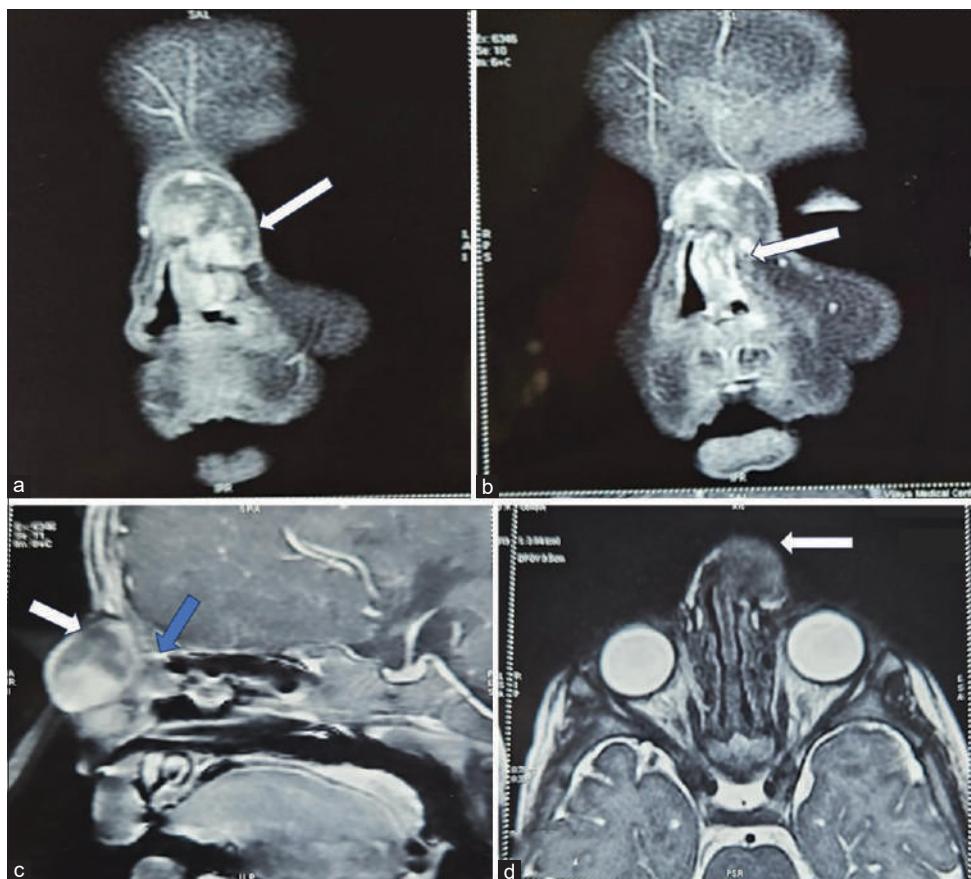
Contrast-enhanced magnetic resonance imaging (MRI) T1 images of paranasal sinuses in the coronal sections (in anterior most plane) showing (a) widening of the nasal dorsum and minimally enhancing mass within the prenasal space on the left side (white arrow); (b) truncation of anterior nasal septum with asymmetry of left nasal cavity (white arrow); Contrast-enhanced MRI (c) T1 sagittal reformatted image in the midline showing extension of a thin soft-tissue signal intensity stalk from the mass up to the foramen cecum (blue arrow), white arrow indicates the nasal mass; (d) T2 axial image revealing the epicenter and extension of the mass
